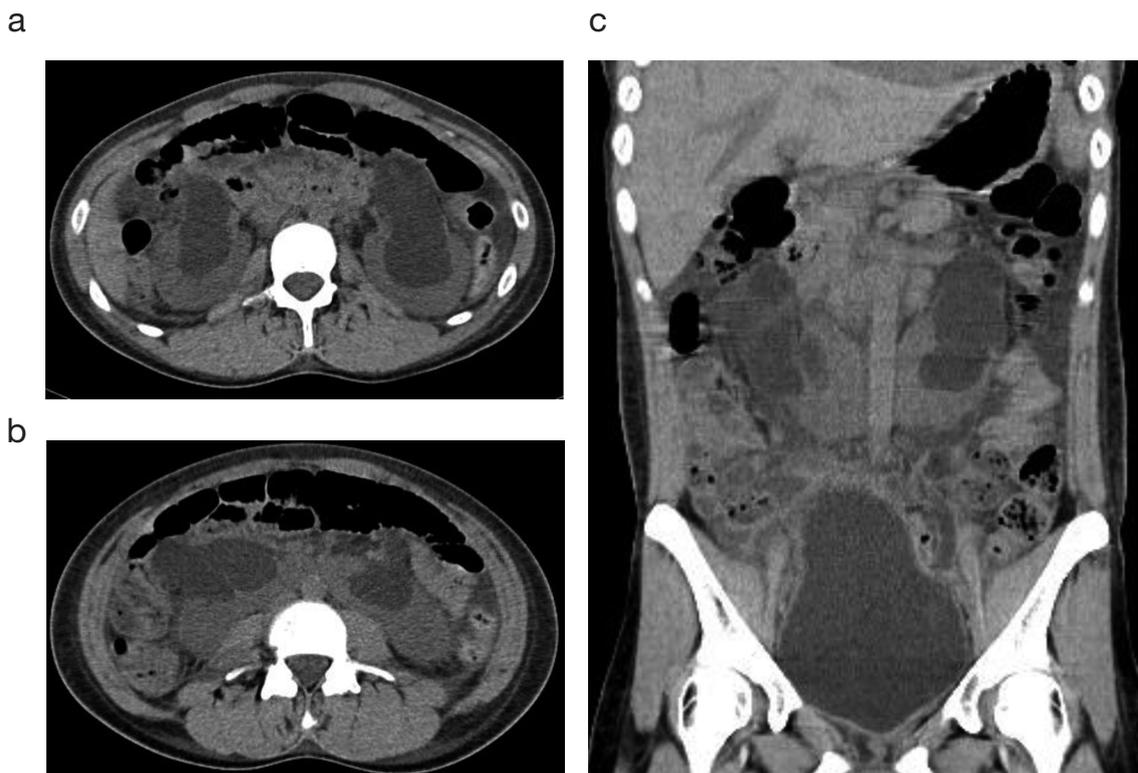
A 20-year-old woman with neurofibromatosis type 1. (a, b) Axial and (c) coronal reformatted computed tomographic images without contrast enhancement show severe hydronephrosis, hydroureter, and neurogenic bladder. (a, c) The appearance of the renal pelvis opening is consistent with horseshoe kidney.
